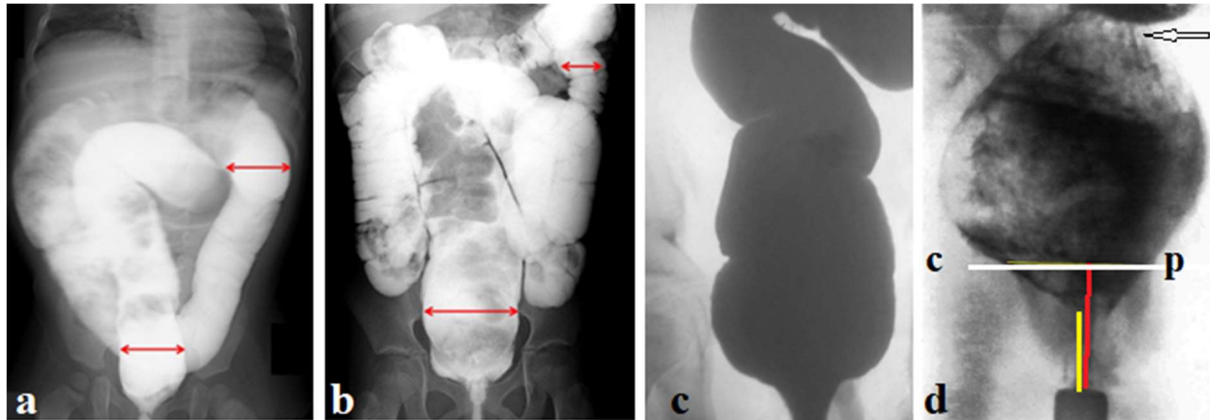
Radiographs (a, b) with contrast enema in patients with FD from the article by Bischoff et al [3]. In both cases, there is an expansion of the rectum and megacolon. (c, d) Radiographs with barium enema in frontal and lateral position of patient 11 years old with FC and descending perineum syndrome. (d) The red line shows how long the anal canal should be at this age. The yellow line is a functioning anal canal. The black arrow shows the contraction of the rectosigmoid sphincter (RSS). White line - pubococcygeal line. The true diameter of the marker located near the anus is 1.6 cm.
